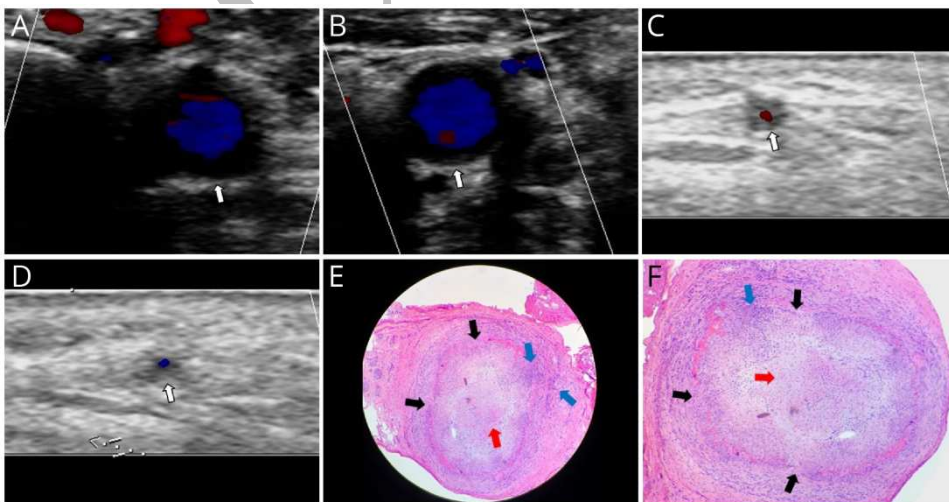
Doppler sonography A-D. Hypoechoic halo (white arrows) secondary to mural inflammation and mural edema in the right common carotid artery (transversal, A), left common carotid artery (transversal, B) and in both temporal arteries (right C and left D). Left temporal artery biopsy E-F. Intimal hyperplasia (red arrow), elastic internal lamina disruption (black arrow) and inflammatory infiltrate with lymphocytes and histiocytes (blue arrow).
